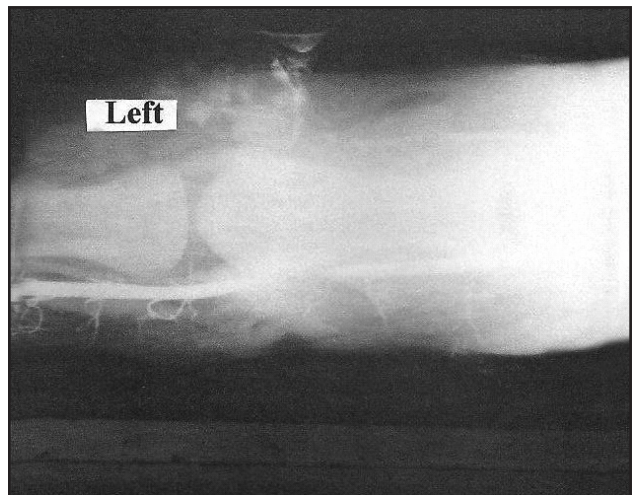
Ventrrodorsal radiograph of neck at level of 3rd cervical vertebrae showing filling of right common carotid artery.
